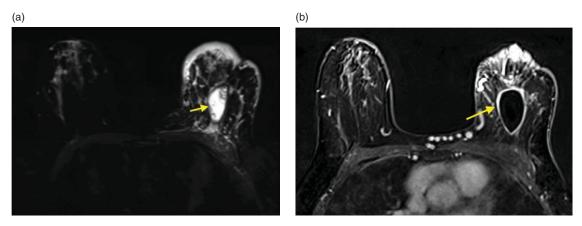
(a, b) Breast MRI (T2 FS and post gadolinium T1) revealed breast oedema with a well-circumscribed oval-shaped breast lesion which shows post contrast rim enhancement.
